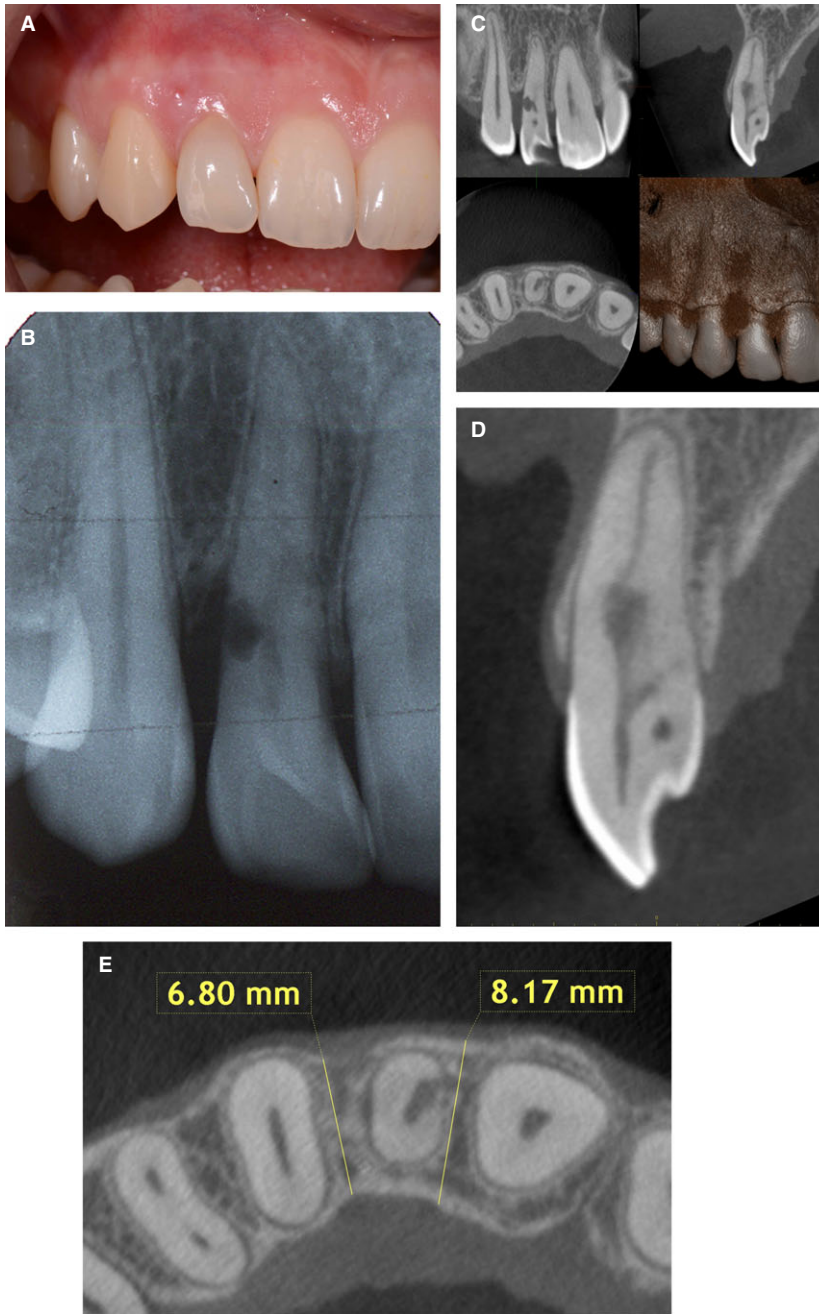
(A) Clinical status of a lateral incisor in the maxilla with increased probing depth at the distal aspect and a fistula about 3 mm from the gingival margin. The patient yields a highly scalloped gingiva and thin soft tissue biotype. Both are high risk factors for implant therapy. (B) The periapical radiograph shows a lesion in the root indicating an external resorption, and a vertical bone loss distal to the root. (C) A 4×4 cm CBCT was made to examine the local anatomy. Several anatomical structures are critical to be examined for a potential implant placement and the respective timing option. (D) The sagittal, oro-facial cut shows a thin facial bone wall, which will be prone for post-extraction resorption due to bundle both resorption. The root resorption is clearly visible. (E) The horizontal cut taken approximately 3 mm apical to the cemento-enamel junction of tooth #12, the crest width mesially and distally of the tooth must be measured. In the present case, the crest measures more than 6 mm, which will provide a 2-wall defect on the facial aspect following implant insertion in a correct, slightly palatal position.
